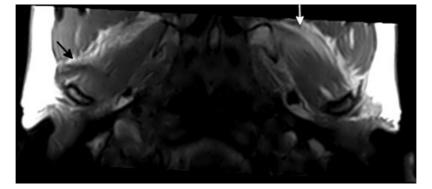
Weight-bearing magnetic resonance imaging, transversal plane. Inhomogeneous signal intensity of the lateral pterygoid muscles due to fibroadipose involution, which is differently represented between the two sides (closer to the condyle on the right – black arrow – and more distant on the left – white arrow).
